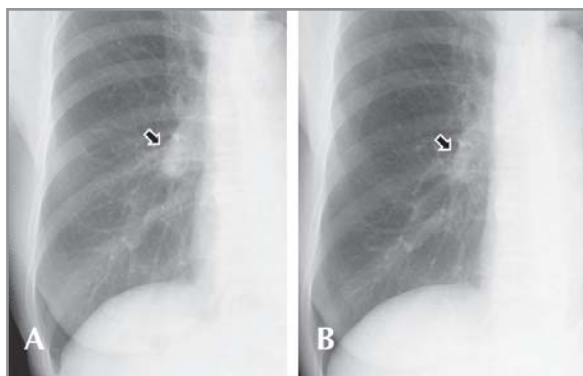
Pre-treatment (A) and post-treatment (B) of chest radiographs.
